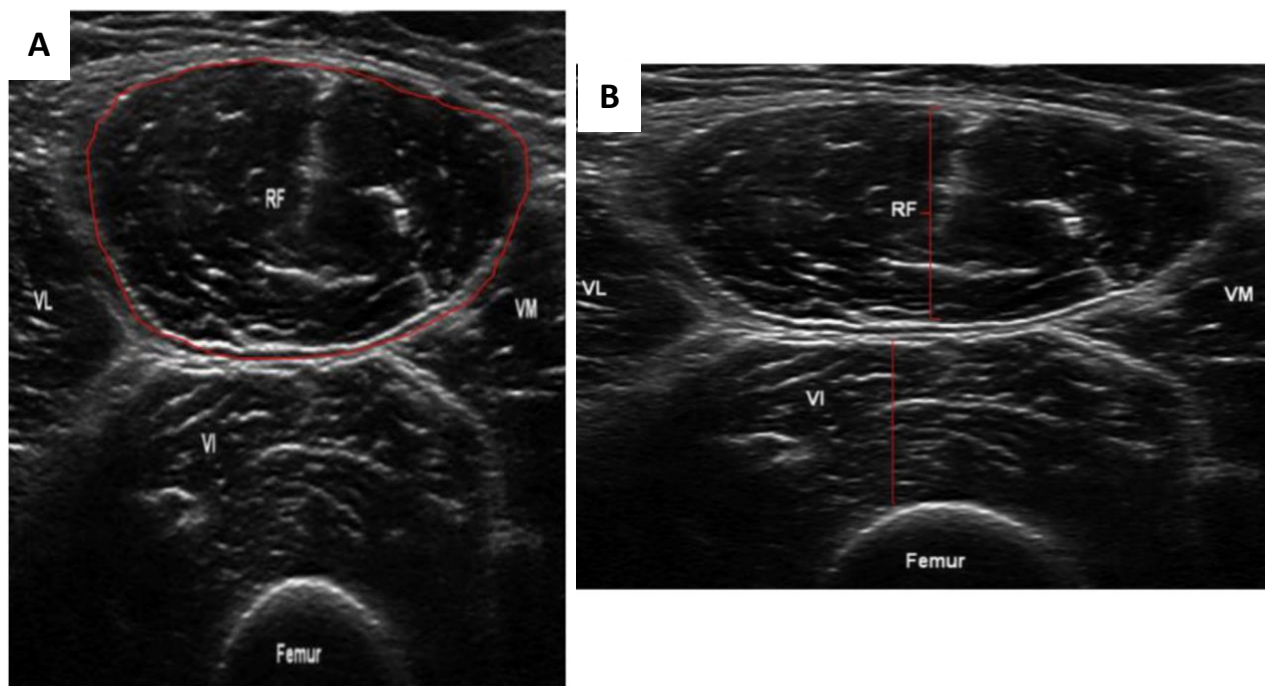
Transverse ultrasound image showing rectus femoris RF cross-sectional area perpendicular to its longitudinal axis (red outline) (A). Muscle thickness measures (red vertical lines) of the rectus femoris and vastus intermedius are also shown (B) (adapted from Formenti et al, 2019).*
